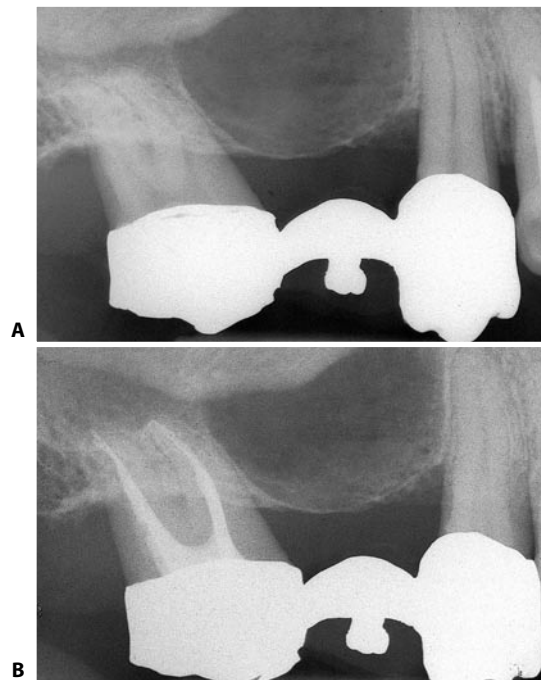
A. Preoperative radiograph of an upper right second molar with two roots. B. Postoperative radiograph. Two canals in two separate roots are visible.
